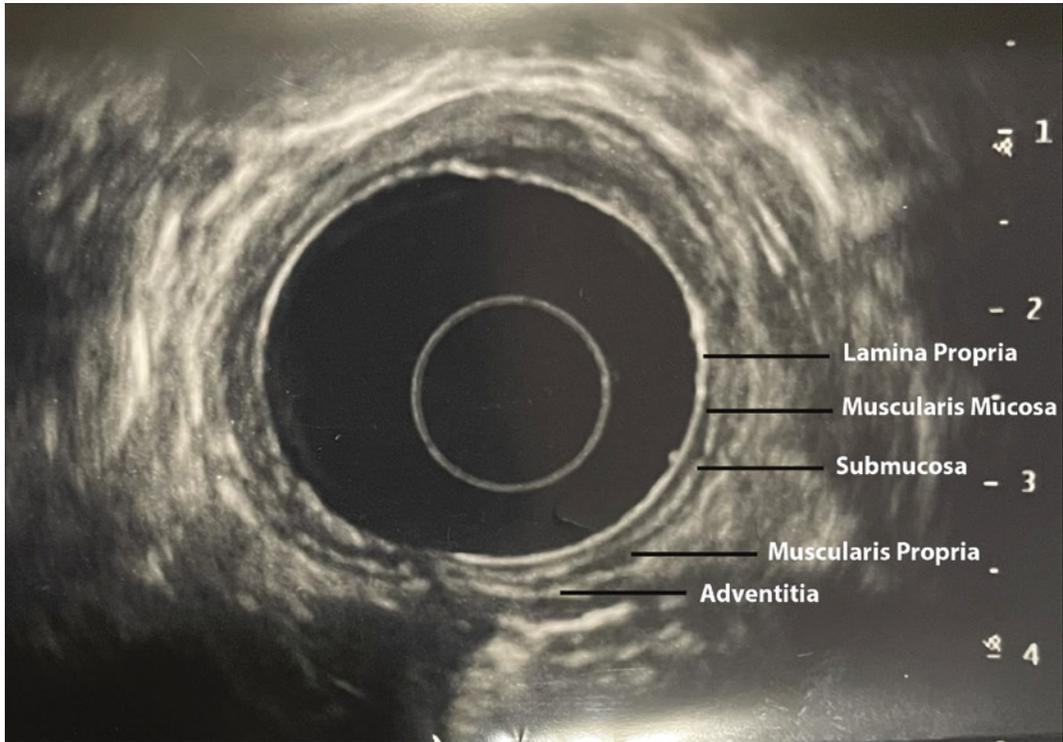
Sonographic layers of the esophageal wall
